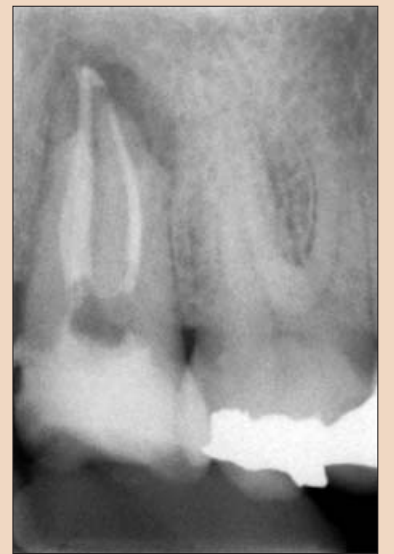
Placement of an immediate coronal restoration with Fugix IX™ (GC America, Alsip, IL) glass ionomer following endodontic therapy with evident periapical lesion. (Courtesy of Dr. Martin Trope).
